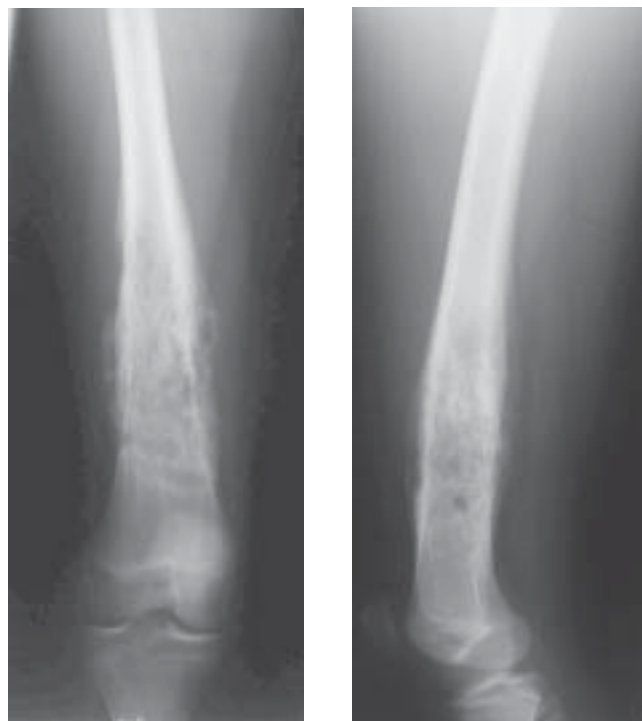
AP and lateral radiographs of the distal femur in case 1, a 13-year-old female with Ewing's sarcoma.
